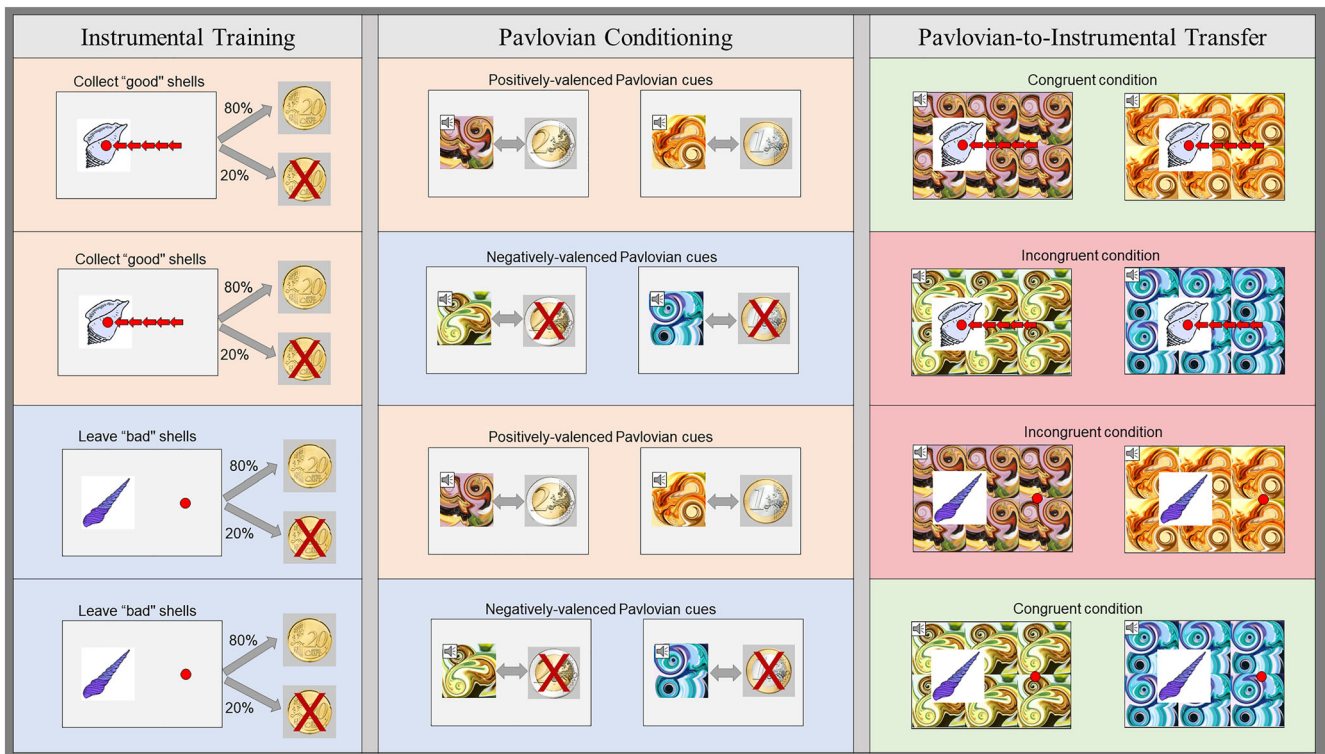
PIT paradigm. Instrumental training: Participants learned to collect good shells (press the button five or more times to move the dot towards the shell; coloured in orange) and leave the bad shells (nothing needed to be done; coloured in blue). A correct response yielded a €0.20 cent reward with the probability of 80% or a €0.20 cent monetary loss with a probability of 20%. After 60 trials, the instrumental training ended if the participants achieved the learning criterion (80% correct choices over 16 trials) or when a total number of 120 trials were reached. Pavlovian conditioning: Participants learned the association between five compound audiovisual stimuli (fractal images paired with pure tones) and the positive (€1, €2; coloured in orange), neutral (€0) and negative (€-1, €-2; coloured in blue) outcomes. The neutral condition is not shown in the figure since this condition cannot be categorized as 'congruent' or 'incongruent'. The Pavlovian conditioning phase consisted of 80 trials, with each fractal appearing 16 trials. Pavlovian-to-instrumental transfer phase: Participants performed the instrumental task again with the fractal images tiled in the background; the pure tones were also played simultaneously. This phase was done in the MRI scanner and under nominal extinction to prevent further learning. Based on whether the Pavlovian background values were concordant with the instrumental stimulus or not, the experimental trials could be categorized into congruent (positively valenced Pavlovian cues with 'good' shells or negatively valenced Pavlovian cues with 'bad' shells; coloured in green) and incongruent trials (positively-valenced Pavlovian cues with 'bad' shells or negatively valenced Pavlovian cues with 'good' shells; coloured in red). Each pairing of instrumental shell and Pavlovian cue appeared nine times during the transfer phase, resulting in 90 trials (9 trials × good/bad shells × five Pavlovian stimuli) in total. Among these trials, 36 trials belonged to the congruent, and 36 trials belonged to the incongruent conditions. Additionally, there were 72 trials during the transfer phase with water or alcohol pictures presented in the background. However, given that we have previously reported that the valence of water and alcohol backgrounds was perceived similarly to the neutral Pavlovian cue (Chen et al 2021), the alcohol/water trials along with the neutral trials were all excluded from the analyses. Query trials: Participants were instructed to select one the two Pavlovian cues presented to them within 2 s. Each possible pair of Pavlovian cues appeared three times in randomized orders. The four phases of the experiment were done in the consecutive order within one experimental session.
